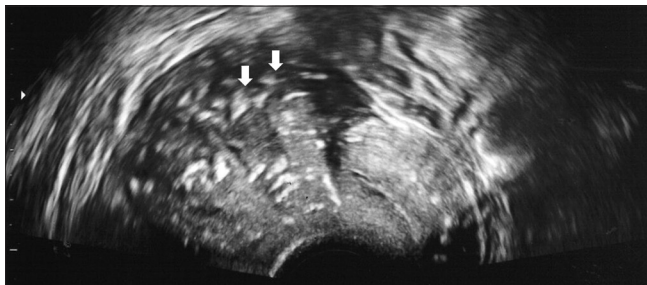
Two-dimensional pelvic ultrasound revealing a heterogeneous uterine wall, with disperse hyperechogenic foci all over the myometrium (white arrows)
